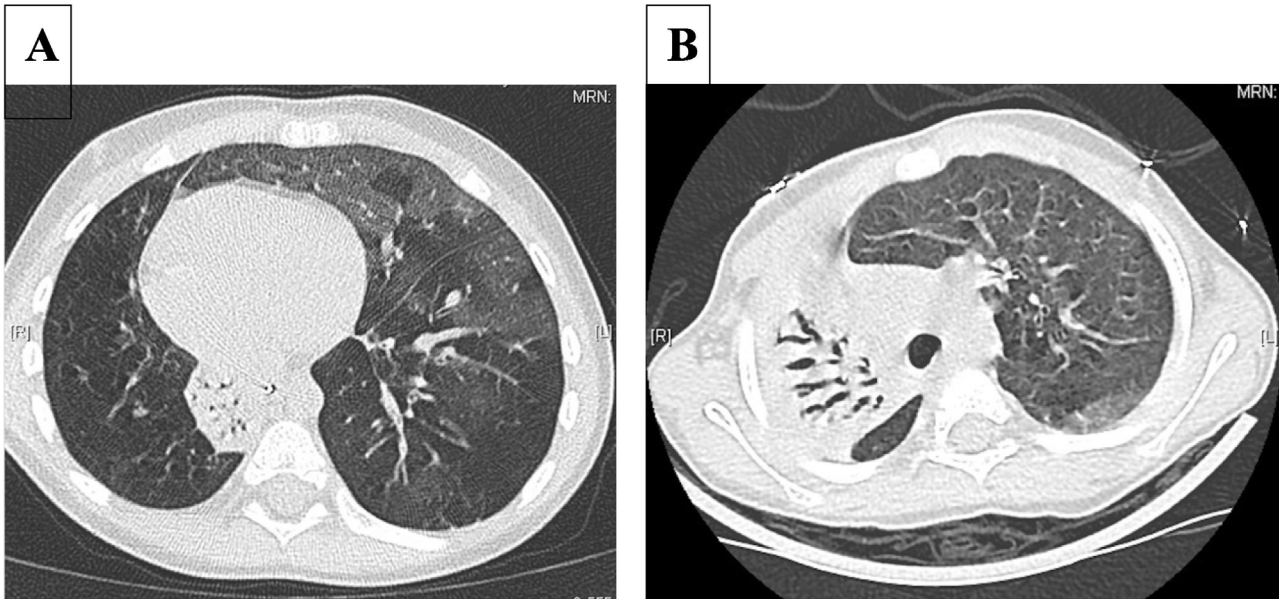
High resolution computed tomography (HRCT). Representative images of the lung from children’s PIBO post adenovirus [5]. (A) Lower right lobe bronchiectasis with mosaic pattern and alveolar hyperinflation. (B) Mosaic pattern on expiratory slides.
